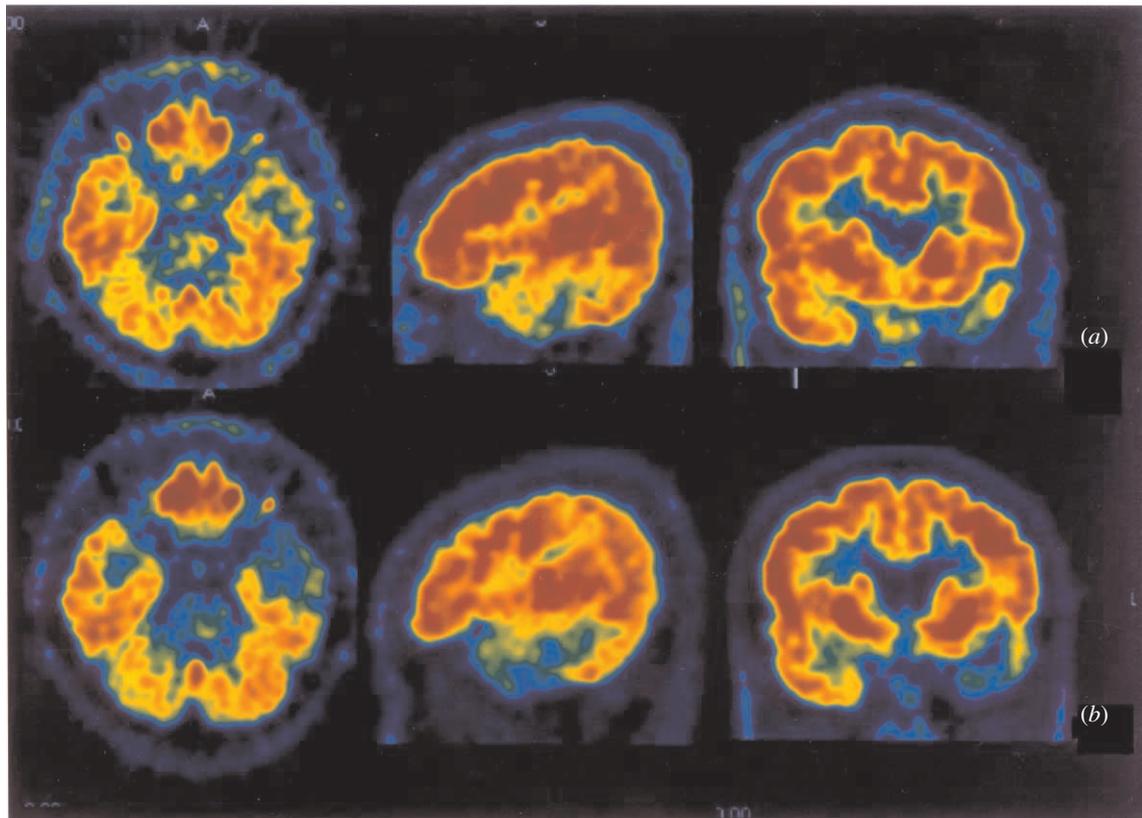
FDG-PET was performed during admission (a) and 4 months later (b). FDG-PET demonstrates glucose hypometabolism in the left anterior temporal lobe which aggravated on follow-up PET despite clinical improvement.
